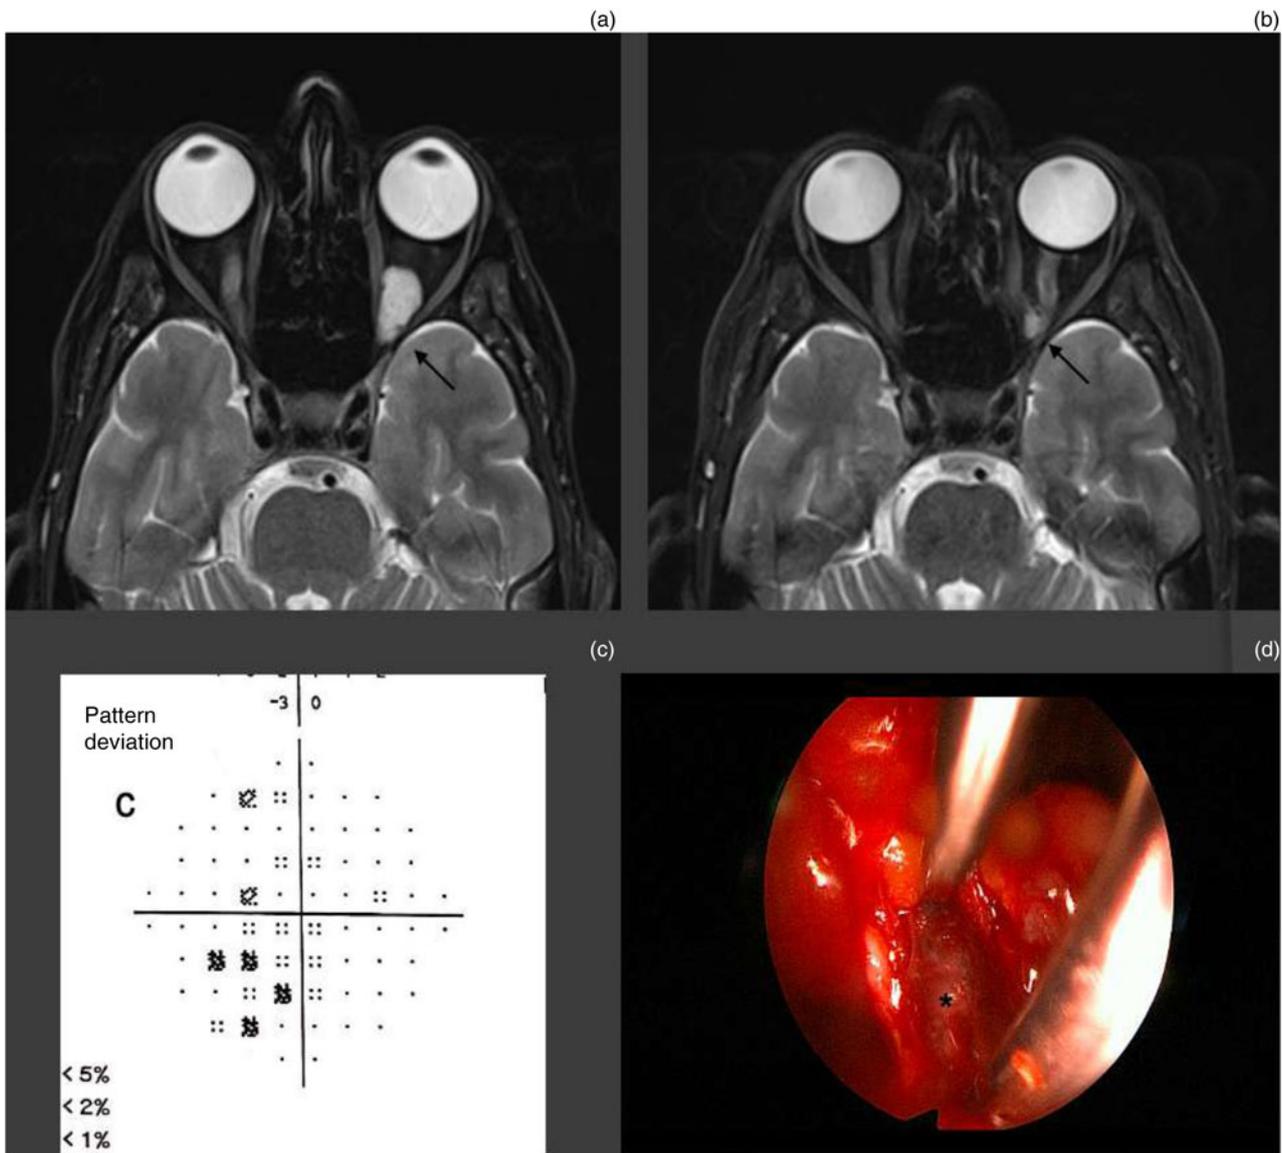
A patient with left orbital apex cavernous haemangioma (patient 4). (a) Pre-operative magnetic resonance imaging (axial T2-weighted sequence with gadolinium). The black arrow points to the tumour. (b) Post-operative magnetic resonance imaging (axial T2-weighted sequence with gadolinium) showing the shrunken tumour post-partial resection. The black arrow points to the tumour. (c) Pre-operative computerised visual field (greyscale) of the patient's left eye showing the visual field defect. The post-operative visual field was normal. (d) Intra-operative endoscopic view. The asterisk indicates the tumour in the orbital apical intraconal fat.
